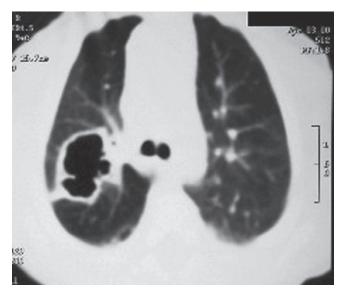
Lung windows of computed tomography study showing right lower lobe abscess.
